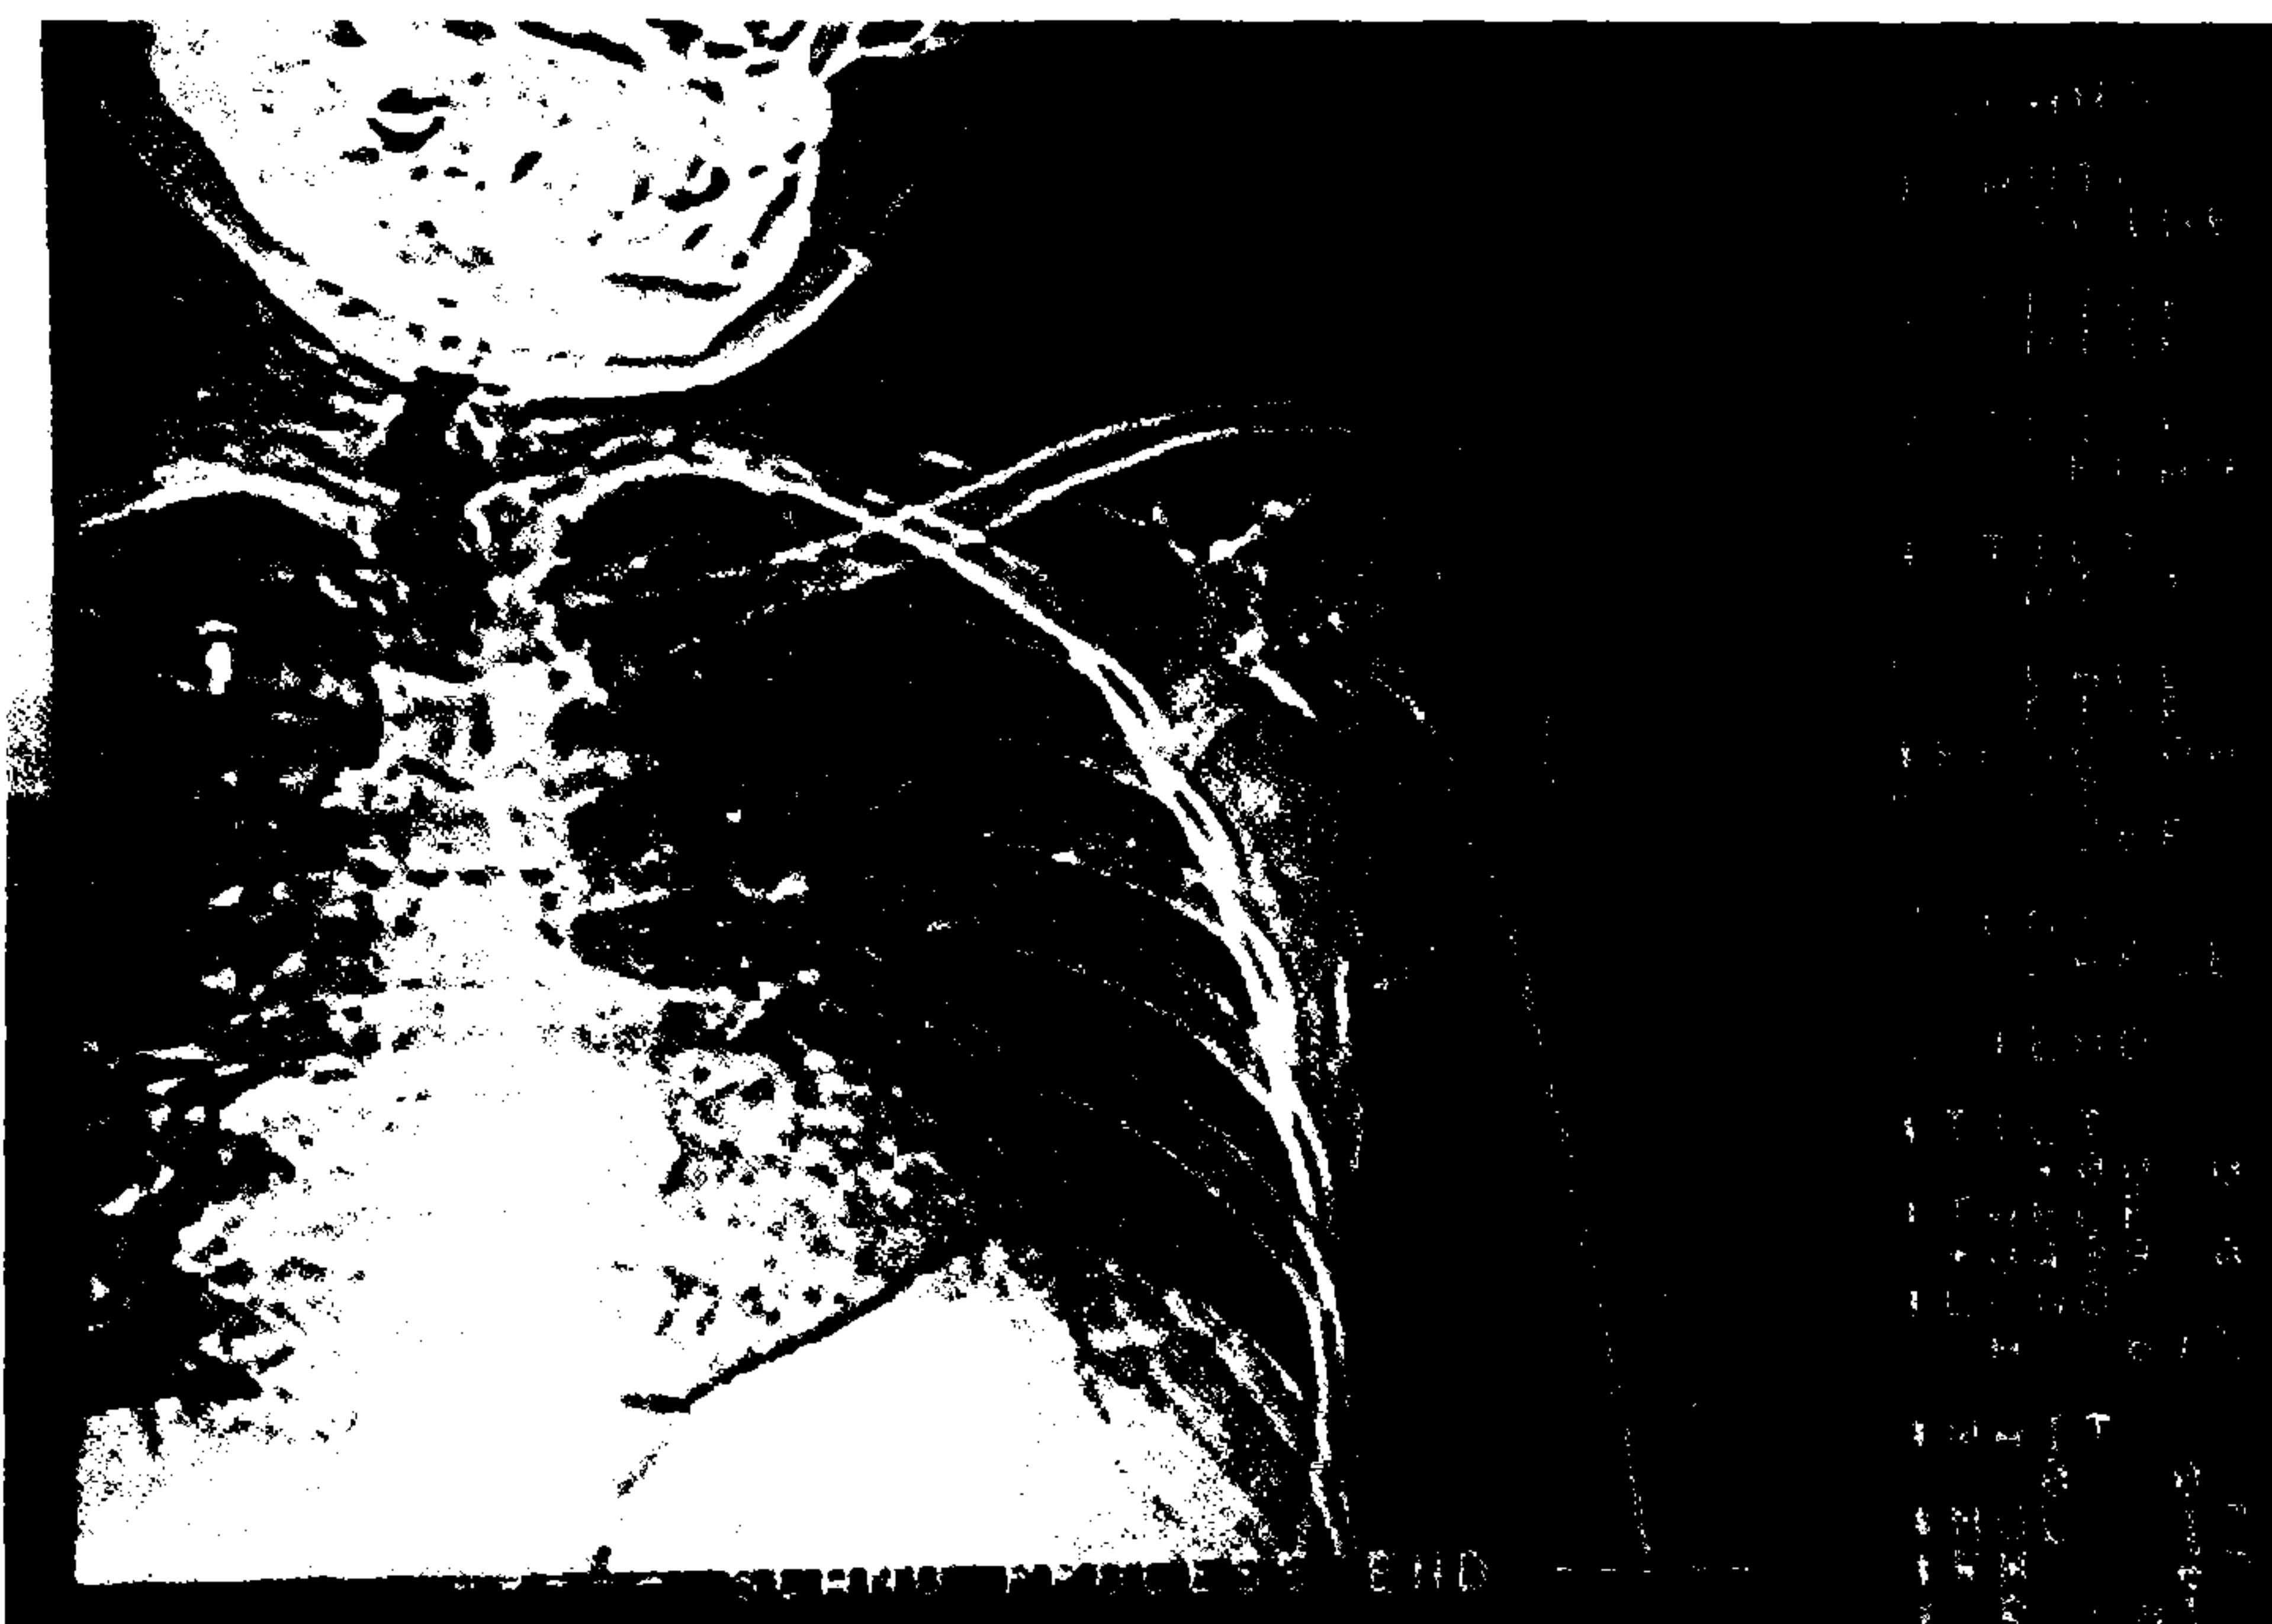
CT image (left shoulder).
